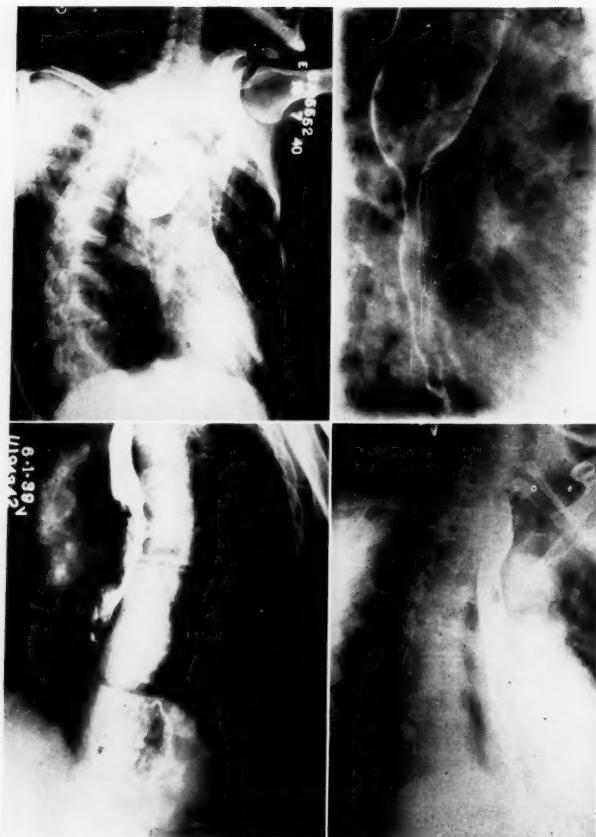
Case H. C. D., No. U-195552. X-ray appearance showing carcinoma of the midesophagus reported by earlier X-rays and esophagoscopies to be a benign stricture.
